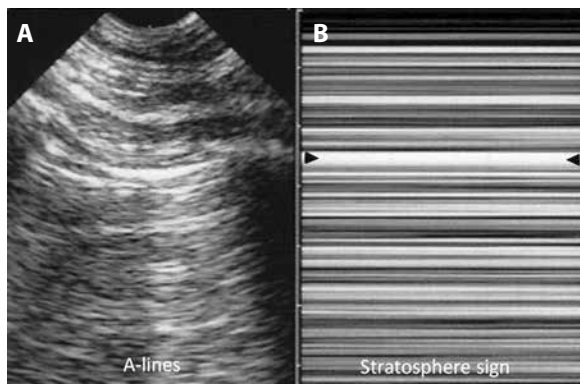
Pneumothorax: stratosphere sign; A — pleural line with A-lines, indicating gas below the pleural line. Although not visible on the left image, lung sliding was totally absent; B — on M-mode, the abolition of lung sliding is visible through the stratosphere sign (which replaces the seashore sign) and indicates total absence of motion. This suggests pneumothorax as a possible cause. Arrows indicate location of the pleural line. The combination of abolished lung sliding with A-lines, at the anterior chest wall, is the A'-profile of the BLUE protocol (as opposed to the A-profile, where lung sliding is present, ruling out pneumothorax). Adapted from 'Lung ultrasound in the critically ill' [11]
